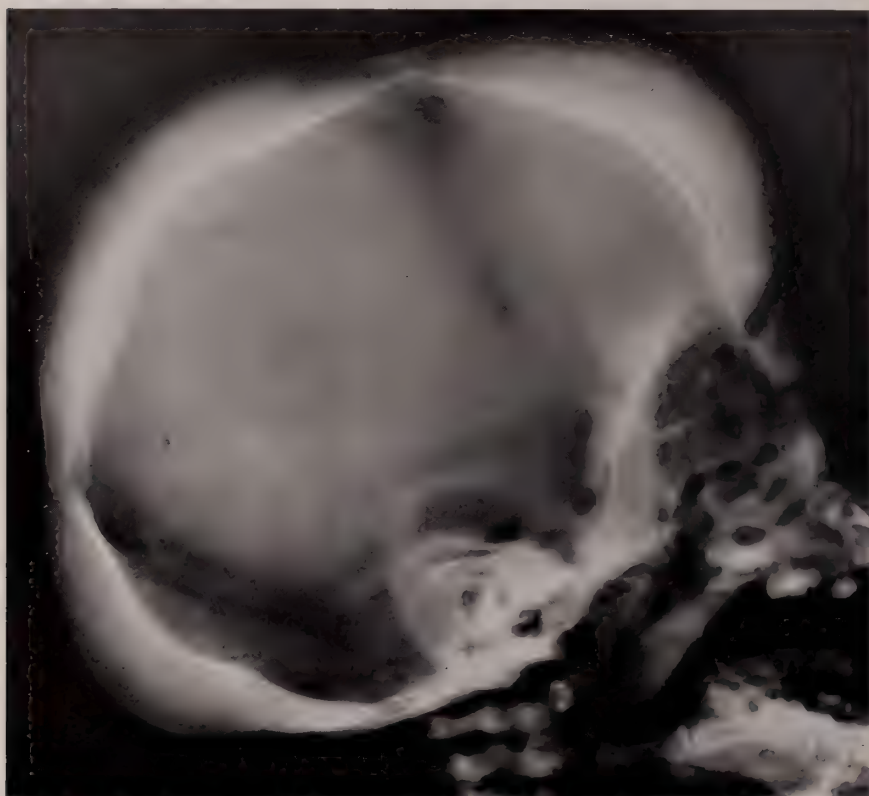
Iron Deficiency Anemia. Same patient at age 2½ years. The diploic space is widened but radial striation of the trabeculae is not yet apparent. There is no swelling of the facial bones. (Moseley, J. E.: *Am. J. Roentgenol. & Rad. Therapy*, 8: 649, 1961.)
